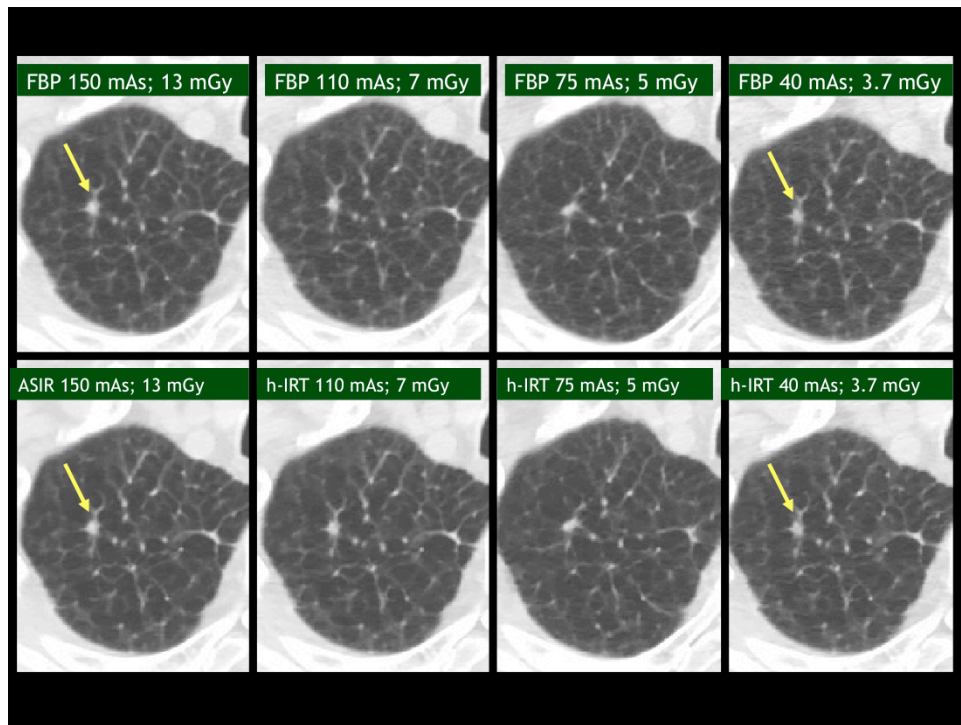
Transverse chest CT images acquired at four tube current levels (150, 110, 75 and 40 mAs) were reconstructed with FBP and iterative reconstruction technique (Adaptive Statistical Iterative Reconstruction, ASIR, GE Healthcare). Both ASIR and FBP images show right upper lobe pulmonary nodule. Although ASIR enabled images shows lower image noise, the visibility of lesions is equal on low dose FBP and ASIR images.
